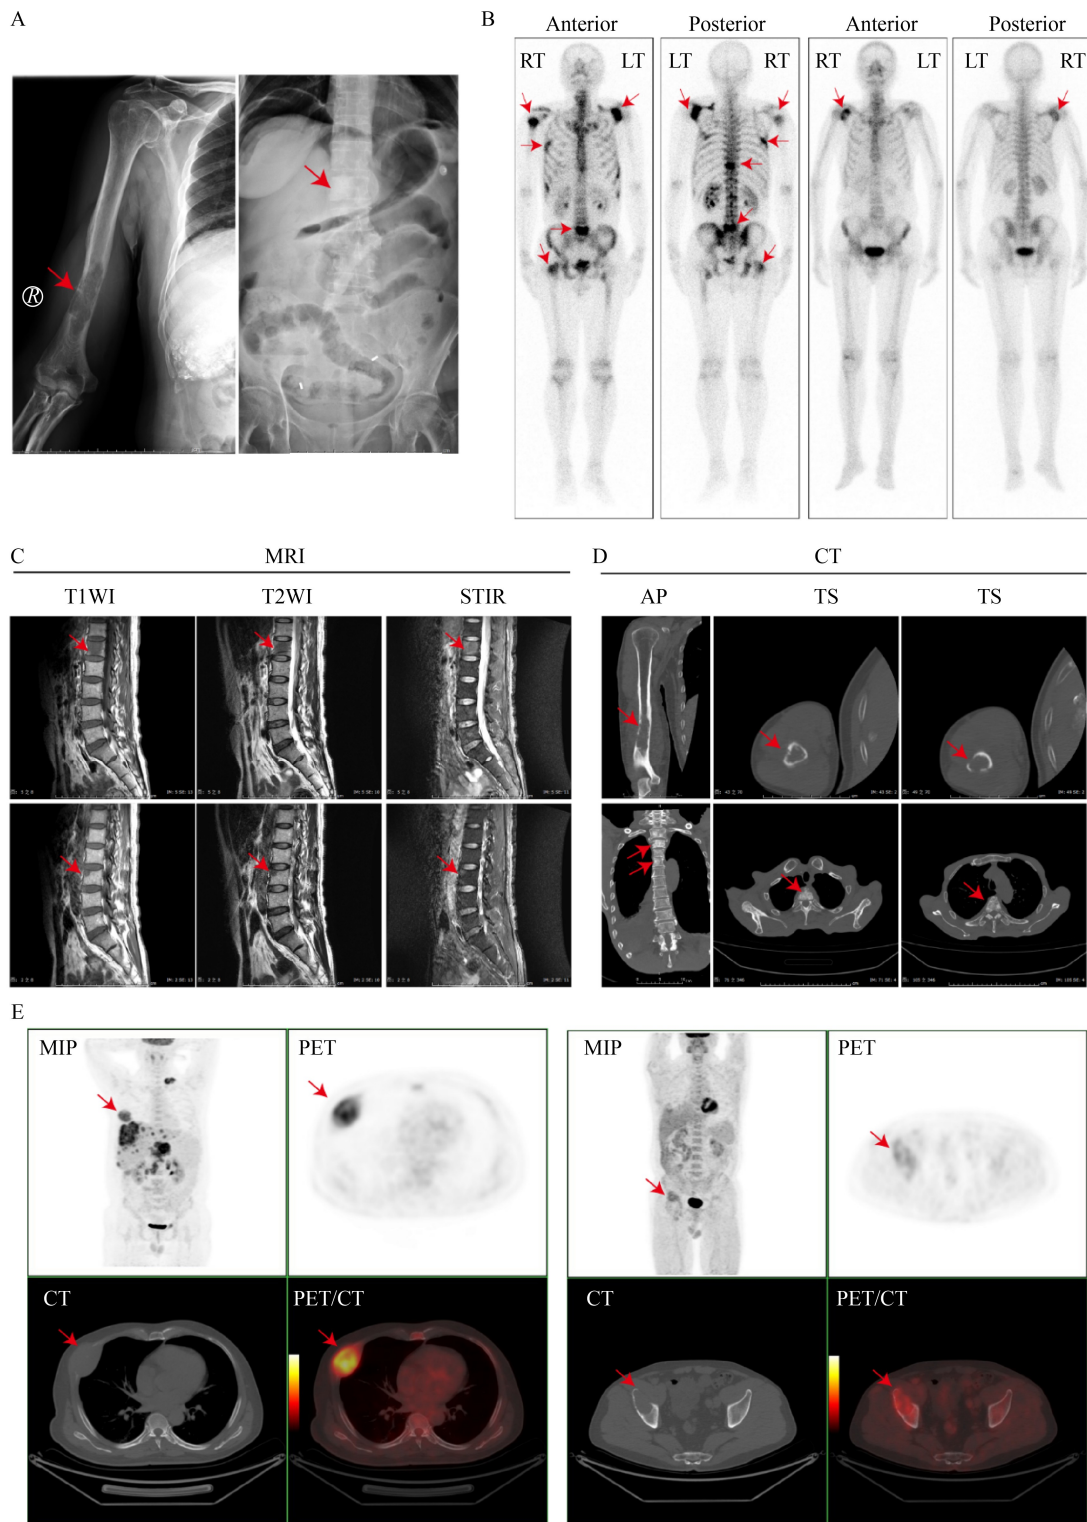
Imaging techniques for the diagnosis of HCC BM. (A) X-ray images of metastatic HCC lesions in the right humerus (left image) and in the L1 vertebral body (right image). (B) Anterior and posterior positions of BS for a patient with multiple BM (left panel) and a patient with a bone lesion in the right scapula (right panel). (C) MRI of skeletal HCC lesions in the L1 vertebral body (upper row) and L3 vertebral body (lower row). (D) CT scans of BM in the right humerus (upper row) and the spine (lower row). (E) Whole-body ^{18}F -FDG PET/CT images of BM in the fifth right rib (left panel) and right ilium (right panel). Arrows point to metastatic HCC bone lesions. Abbreviations: CT, computed tomography; BS, bone scintigraphy; MRI, magnetic resonance imaging; PET, positron emission tomography; BM, bone metastasis; LT, left; RT, right; AP, anteroposterior; TS, transverse section; T1WI, T1 weighted image; T2WI, T2 weighted image; STIR, short time inversion recovery; MIP, maximum intensity projection.
